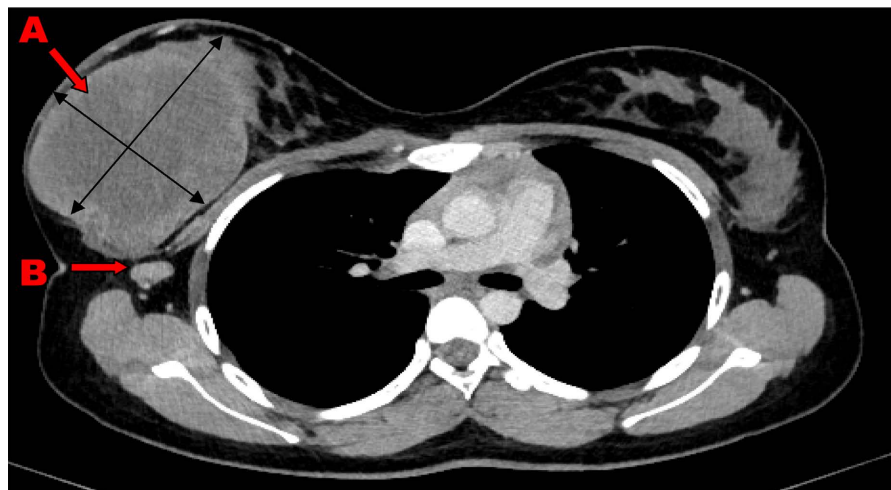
Axial section of a chest CT scan, injected, showing a right breast mass $128 \times 104 \times 89$ mm (A), associated with ipsilateral axillary lymphadenopathy (B).
